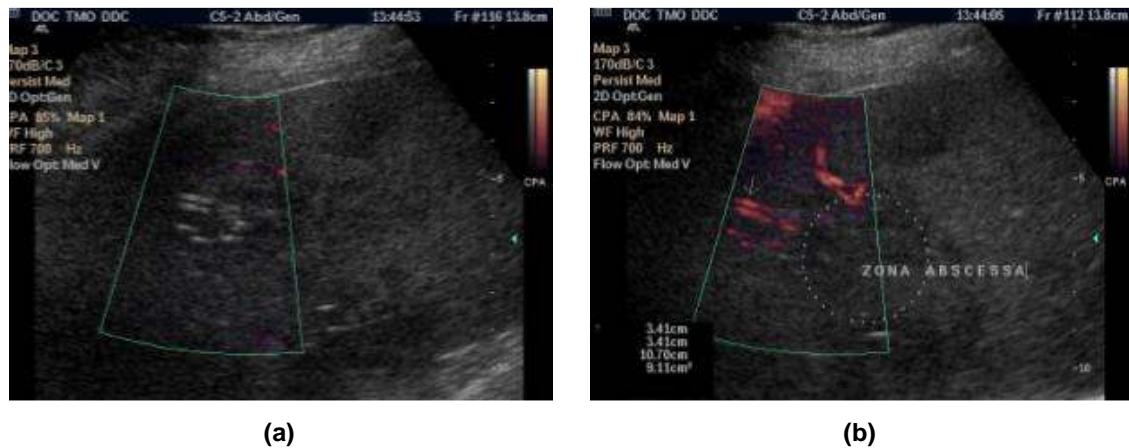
Doppler visualization of vessels at intended biopsy area of kidney
